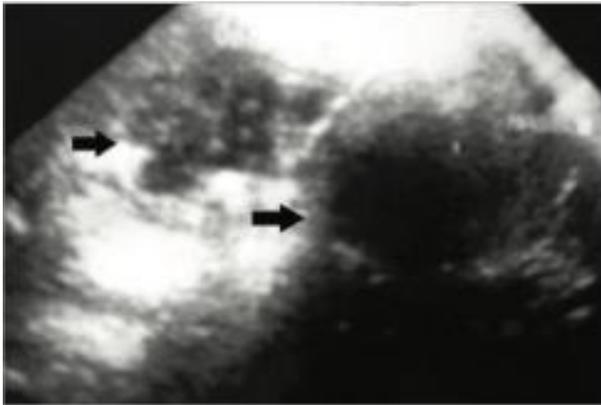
partially calcified hydatid cyst with gallbladder deformation on ultrasound
